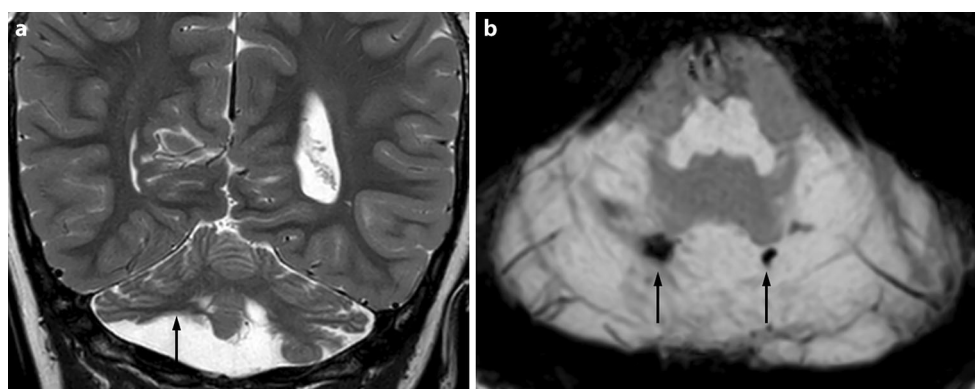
a, b Magnetic resonance images of the brain in an 8-year-old female patient of short stature primarily sent for evaluation of the pituitary gland. The coronal T2-weighted turbo spin echo (TSE) image depicts irregular volume reduction at the base of both cerebellar hemispheres with right-sided predominance (a, arrow). The axial susceptibility-weighted image (SWI) shows bilateral focal signal loss (b, arrows) posterior to the lateral recess of the enlarged fourth ventricle, most likely representing hemosiderin deposits. The imaging pattern is compatible with cerebellar disruption due to hemorrhage
